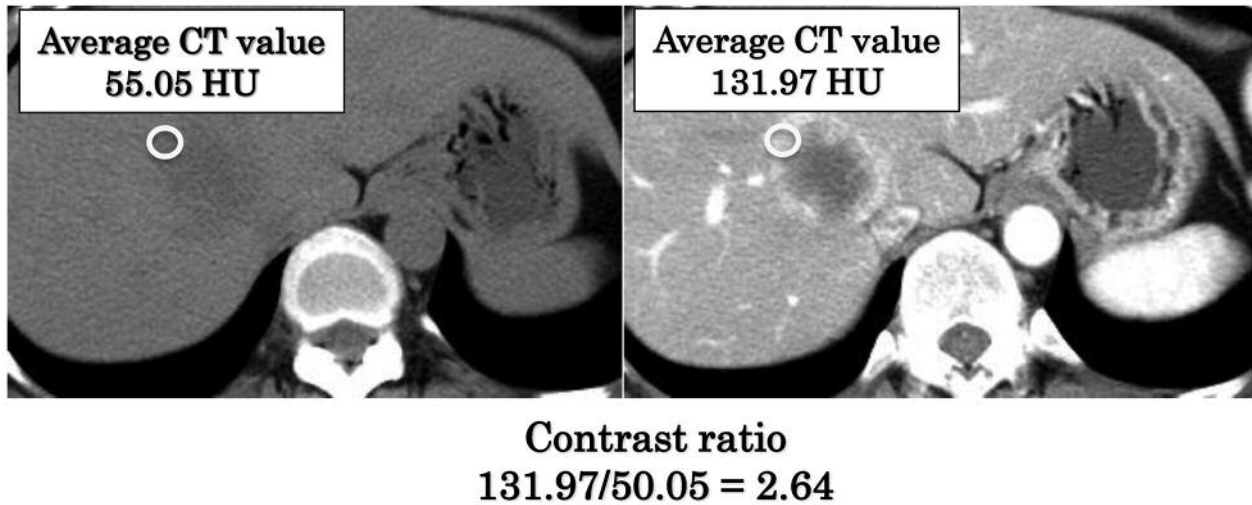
For the evaluation of the marginal area of the metastasis, regions of interest (ROIs) were set at the same peripheral portion of the metastasis in both the late arterial phase and the plain computed tomography (CT). The mean CT ratio of the marginal area was obtained using three ROIs of metastasis from each patient.
